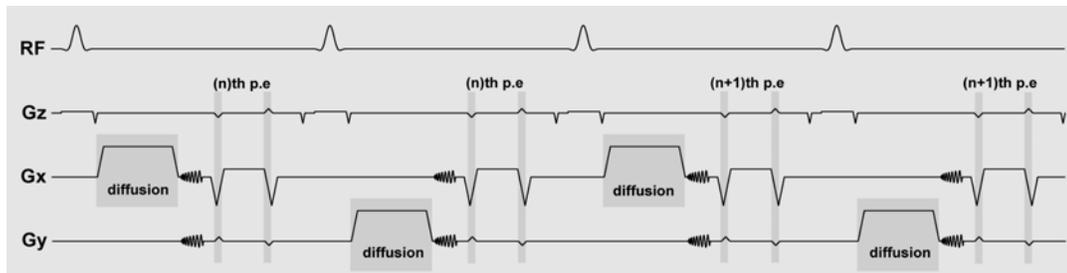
Four  $T_{RS}$  of the isotropic steady-state DWI pulse sequence with a 3DFT acquisition and a 2D spiral navigator. The diffusion gradient alternates between  $G_x$  and  $G_y$ . The phase encoding changes every other  $T_R$ .
